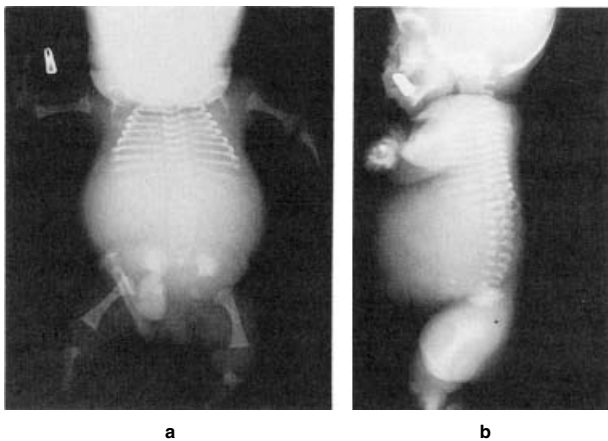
Radiographs of an infant with hypochondrogenesis (a, b), showing similar but less severe findings than in achondrogenesis type II. Note ossification of the vertebral bodies.
